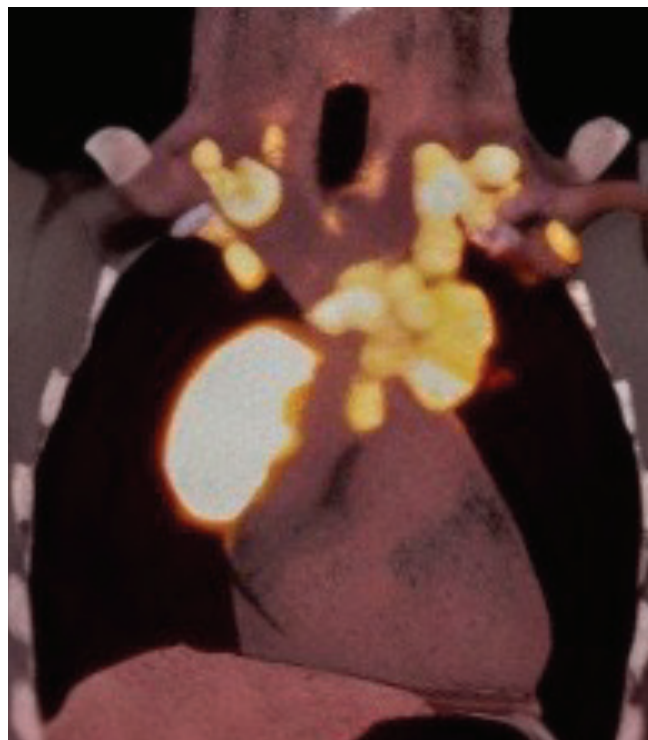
PET-CT image of a patient with an anterior mediastinal mass and multiple mediastinal lymph node involvement, who underwent left supraclavicular lymph node excision (SUVmax: 19.2) and was diagnosed with Diffuse Large B-Cell Lymphoma.
